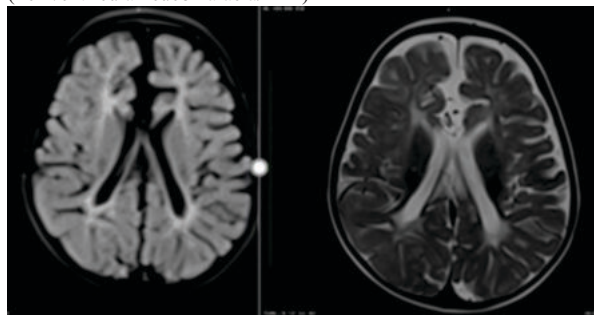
Partial Dysgenesis Of Anterior Portion Of Corpus Callosum With Periventricular Leucomalacia, Dilated Lateral Ventricles As Seen On Axial FLAIR (Right Image) As Well As T2 Axial Left Sided Image.
